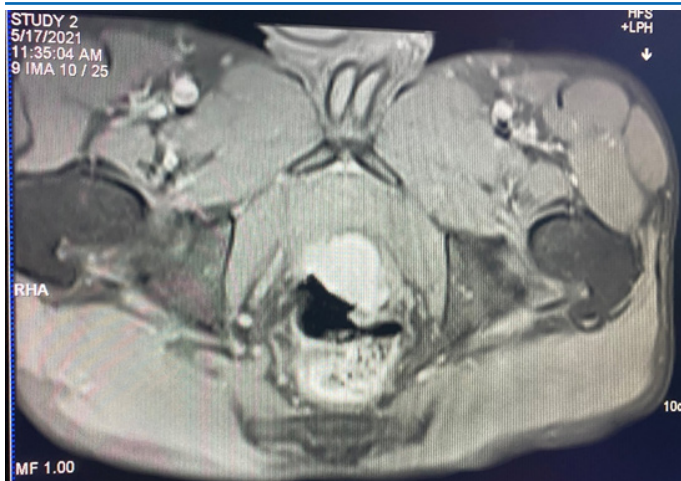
MRI showing asymmetrical circumferential thickening in anal canal region (red arrow)
